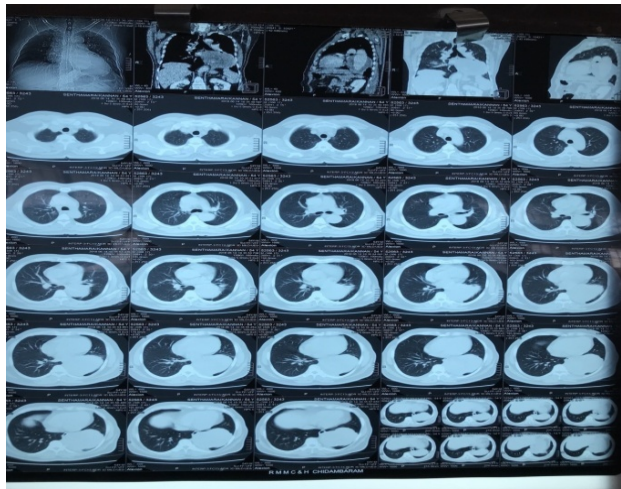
CT angiogram of Thorax
